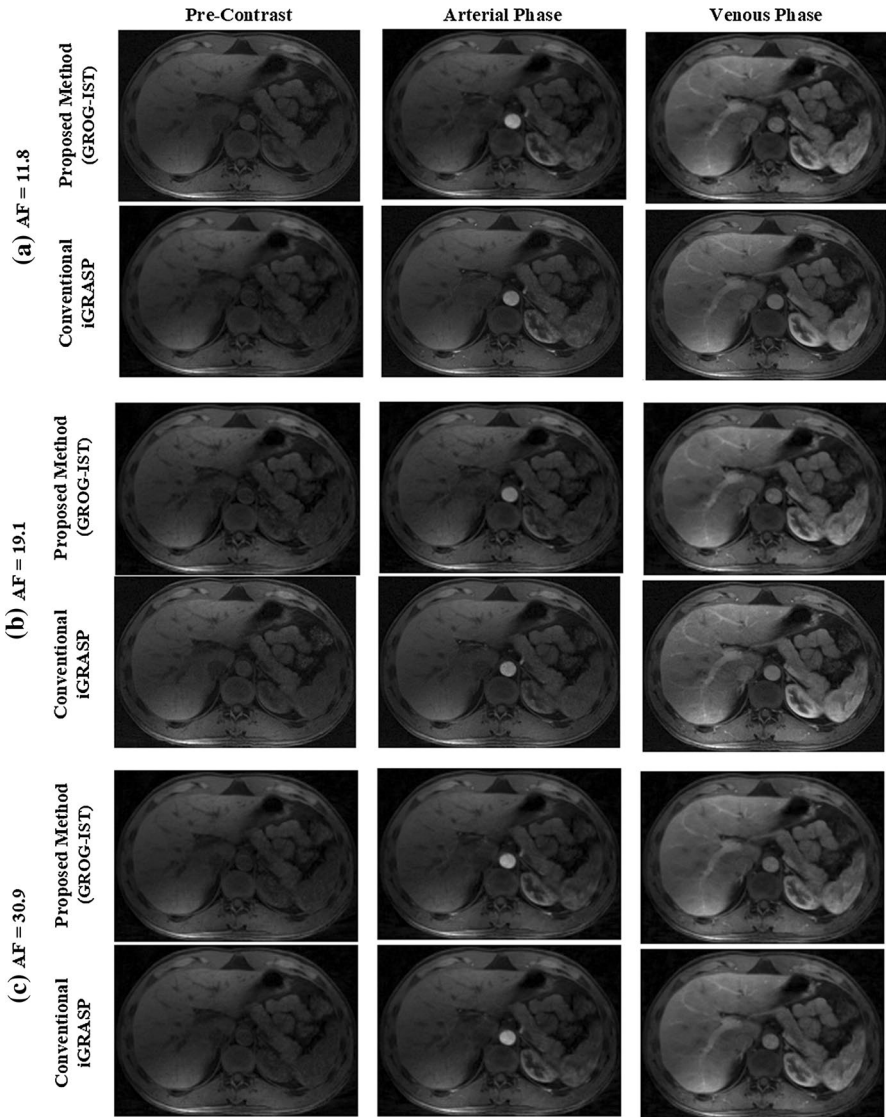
Reconstruction results for the proposed method and conventional GRASP at different acceleration factors (AF): (a) AF=11.8 with 17 temporal frames having 34 radial spokes/frame; (b) AF=19.1 with 28 temporal frames having 28 radial spokes/frame; (c) AF=30.9 with 46 temporal frames having 13 radial spokes/frame of DCE-MRI golden-angle radial data in pre-contrast, arterial and venous phases of liver perfusion
